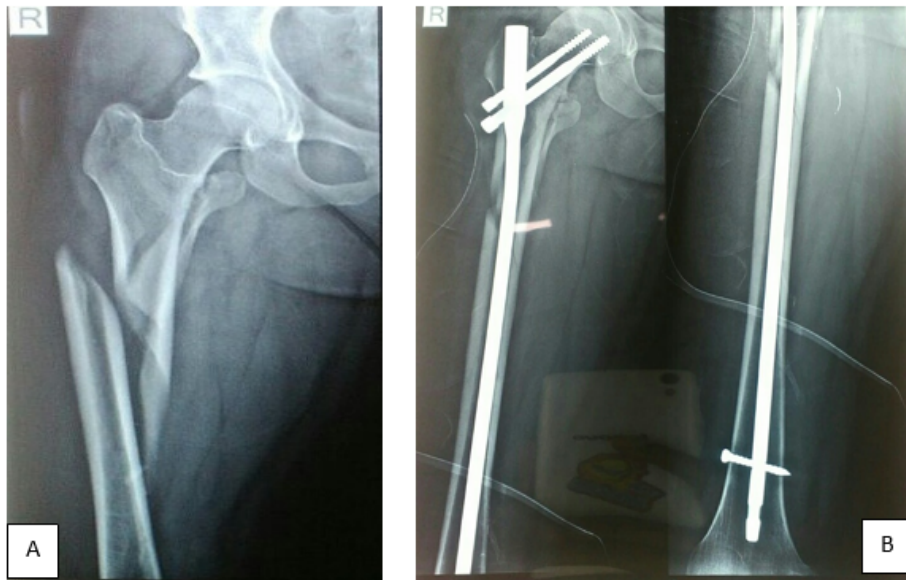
A: Pre-operative X-ray; B: Post-operative X-ray
